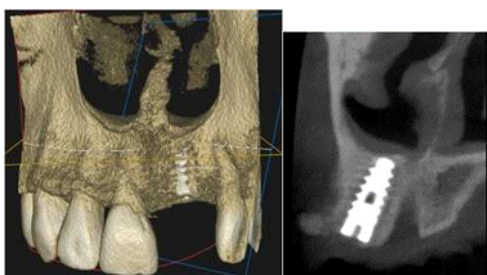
Radiographic evaluation (osseointegrated implant)
